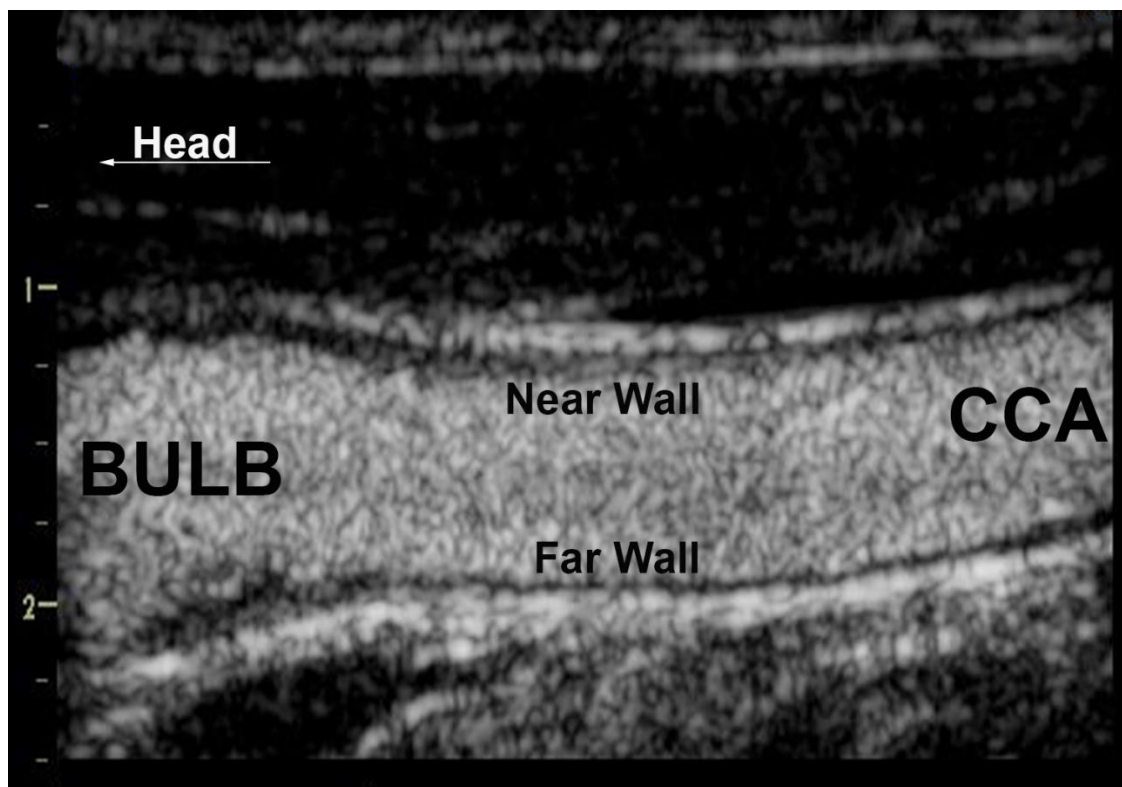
Contrast enhanced ultrasound image of a human common carotid artery (CCA). The tunica adventitia is seen as an echo-bright structure whilst the intima-media complex is black in CEUS imaging, providing clear definition against the white appearance of the contrast bubbles within the arterial lumen.
